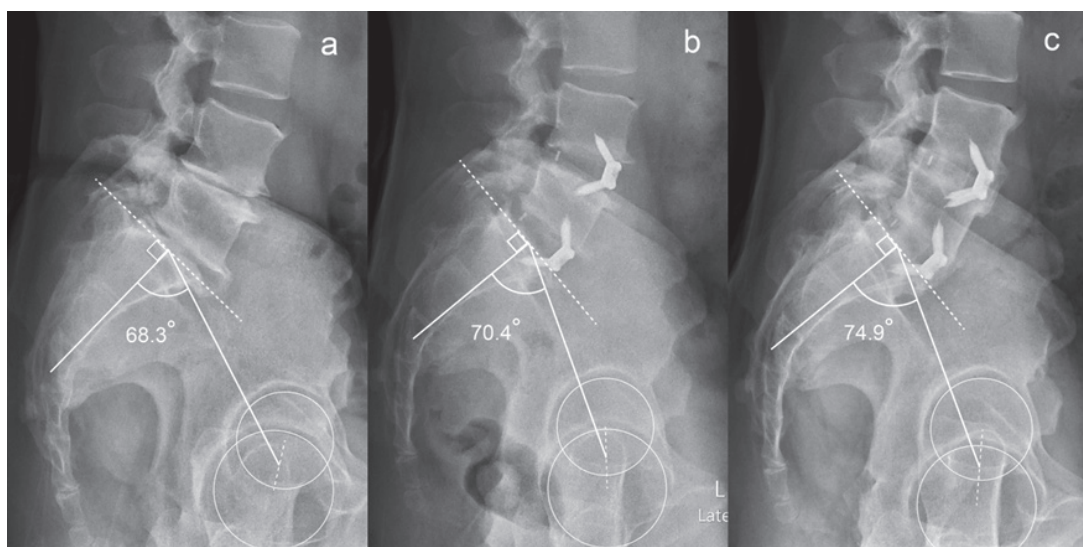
52-year-old male received a L4-S1 ALIF surgery for degenerative disc disease. Preoperative (a), 6-week postoperative (b) and 1-year postoperative (c) standing lumbosacral lateral radiographs. Note the pelvic incidence (PI) increments. Preoperative PI was 68.3°, 6-week postoperative PI was 70.4° with Pelvic incidence disparity (Δ PI) as 2.1°. PI at 1-year postoperative follow-up increased to 74.9° with Δ PI 6.6°.
